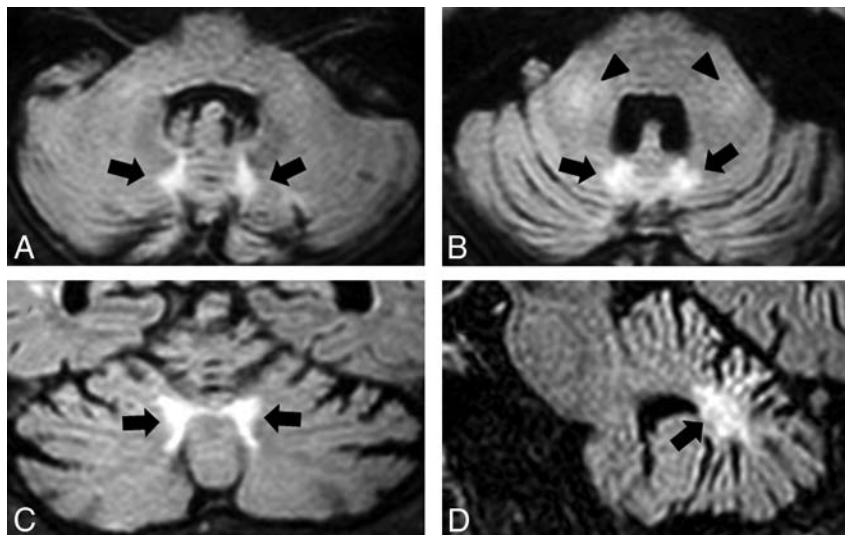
A representative case (patient 1) showing the abnormal signals at the paravermal area and the middle cerebellar peduncle. FLAIR axial images (A and B), a coronal image (C), and a sagittal image (D) show atrophy of the cerebellum and bilateral high signal intensity in the medial part of the cerebellar hemisphere immediately beside the vermis (the paravermal area) (black arrows) and in the middle cerebellar peduncle (black arrowheads).
